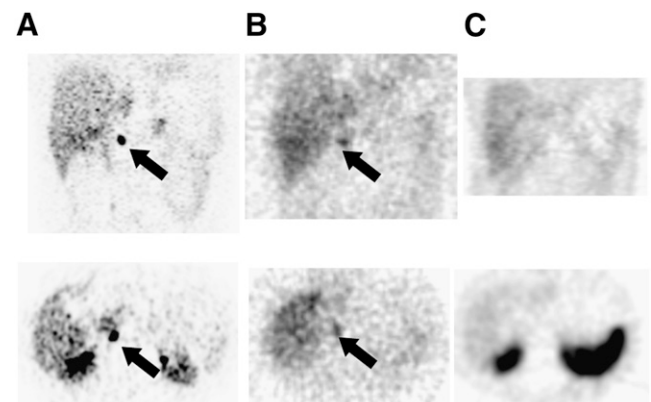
Coronal (upper row) and transverse (lower row) ^{18}F -DA (A), 24-h ^{123}I -MIBG (B), and 4-h SRS (C) images of 23-year-old man with nonmetastatic recurrent right adrenal PHEO. ^{18}F -DA PET and ^{123}I -MIBG scintigraphy are both positive (arrows), whereas SRS is negative.
